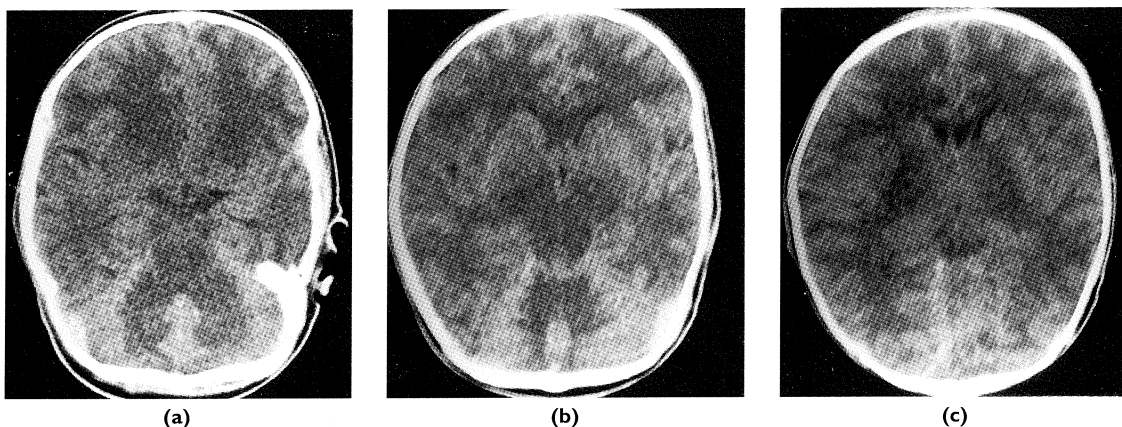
The computed tomography of the brain at the onset of illness showed diffuse oedema, with marked hypodensity in the (a) deep cerebellar white matter and brain stem; (b) cerebral peduncles and (c) thalamus and posterior limbs of the internal capsule. The frontal horns of the lateral ventricles and Sylvian fissures are effaced (b).
